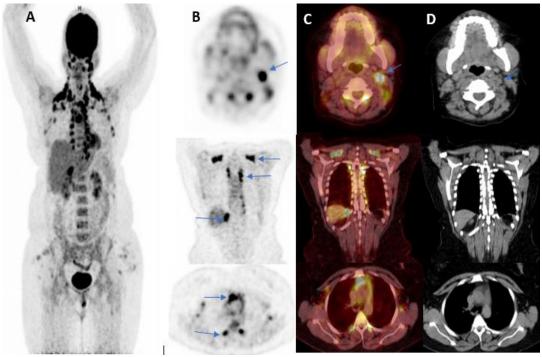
A 40-year-old female diagnosed with non-Hodgkin's lymphoma, B cell subtype, (A) maximum intensity projection image shows extensive brown fat uptake in the six regions (cervical, supraclavicular, mediastinal, axillary, paravertebral, and perinephric regions). (B) coronal and transaxial PET images, (C) coronal and transaxial PET/CT fused images, and (D) the corresponding CT reveal that 18F-FDG uptake corresponds to fatty tissue (HU of -113). The first row shows metabolically active cervical LNs; the accurate judgment of SUVmax and Deauville score cannot be assessed due to overlapping BAT activity.
